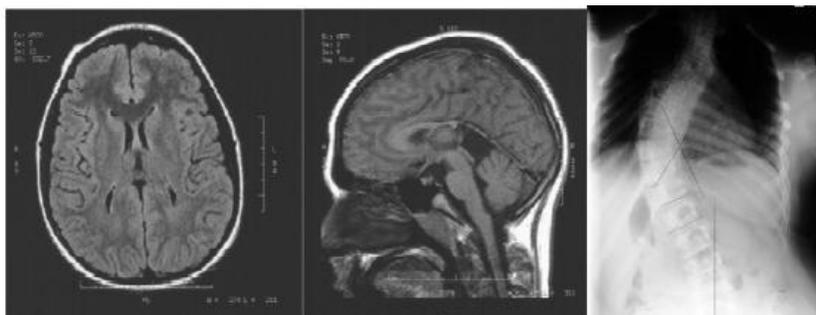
(a) Magnetic resonance images of the brain of a 12-year-old male with a pineal cyst. (b) Plain AP radiograph demonstrating his right thoracic scoliosis.
